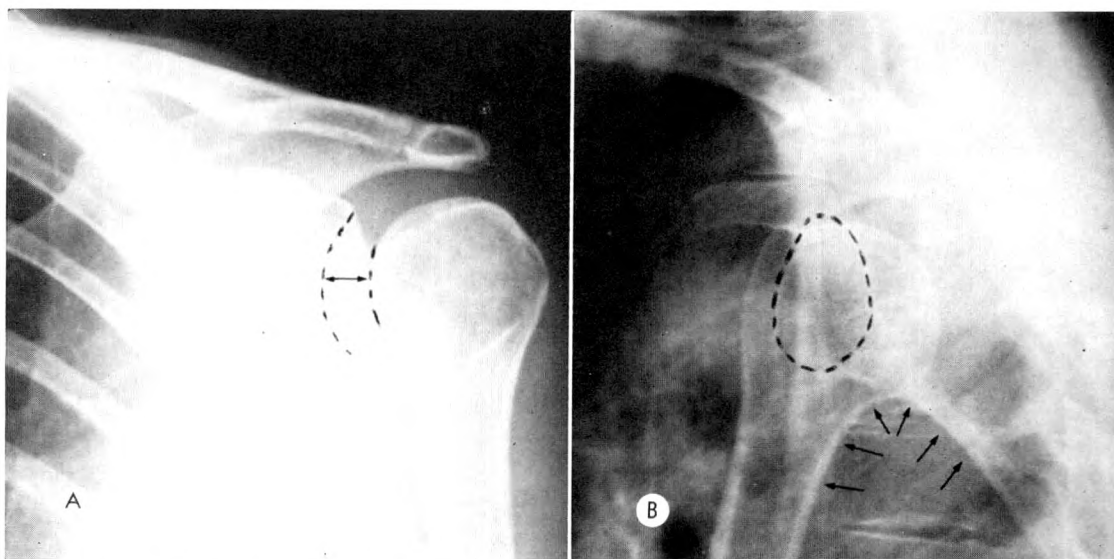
Case I. Positive rim sign. (A) The humerus is in internal rotation, yet the space between the medial margin of the humeral head and the anterior rim of the glenoid fossa ( $\leftrightarrow$ ) measured 11 mm. (B) Transthoracic lateral roentgenogram. Rounded articular surface of humerus faces posteriorly and does not engage the glenoid fossa (dotted oval). Apex of scapulohumeral arch is narrowed (arrows). Compare with Figure 4B.
